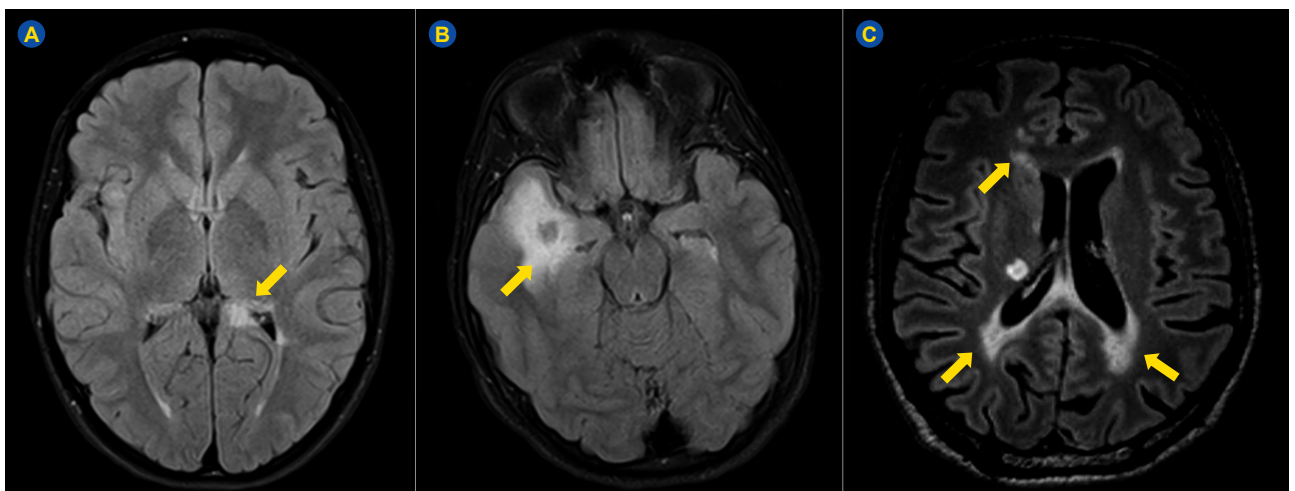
T2 WI FLAIR axial images of diffuse lesions with poorly defined borders (arrows). MRI scan of a 16-year-old girl (A) and from a 13-year-old girl (B) at diagnosis. MRI scan from 51-year-old man at diagnosis (C).
